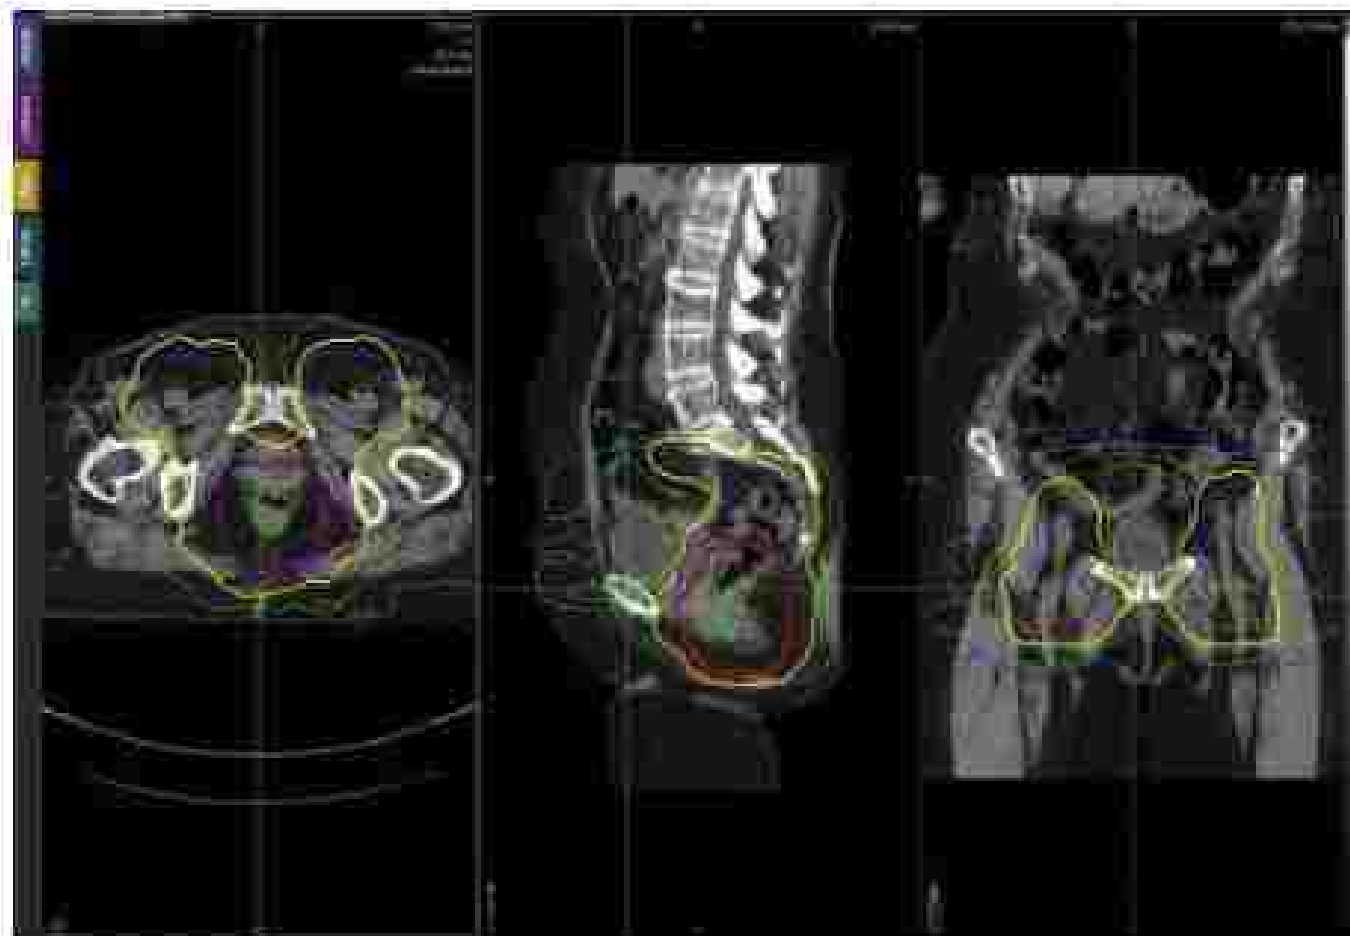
Axial, sagittal, and coronal dose distributions of a planning computed tomography scan for intensity-modulated radiation therapy. Each contour line corresponds to a specific radiation dose. (Courtesy of Alvario Hernandez, M.D., M.Sc., Ph.D.)
